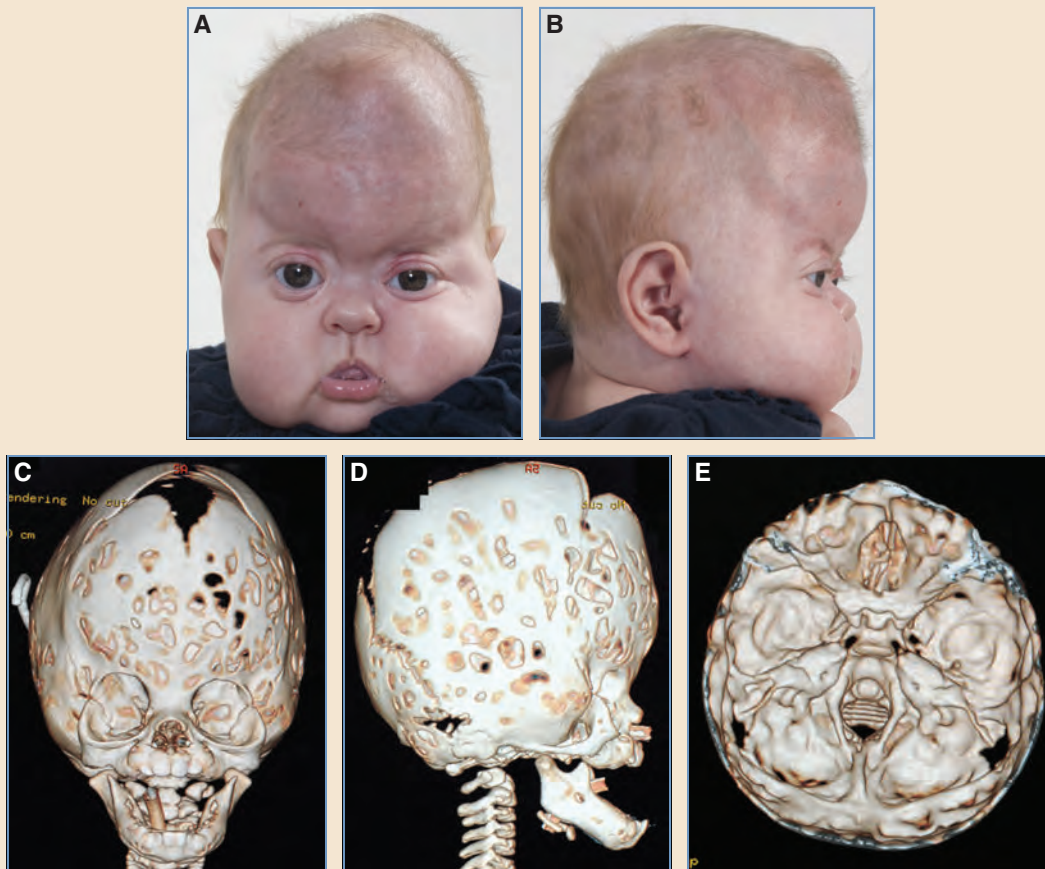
A and B, This infant has Crouzon syndrome, with severe exorbitism, a bulging forehead, and bilateral temporal bulges. C-E, CT scans show severe thumbprinting, bicoronal synostosis with temporal squamosal and metopic involvement, and midface retrusion.
